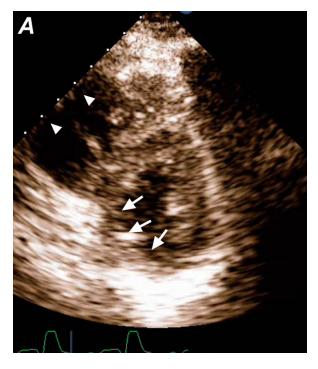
Transthoracic echocardiograms obtained in A) systole and B) diastole (parasternal short-axis mid-cavity view) show a dilated right ventricle with an akinetic free wall (arrowheads) and a contracted left ventricle with akinetic inferior and inferoseptal wall segments (arrows).
